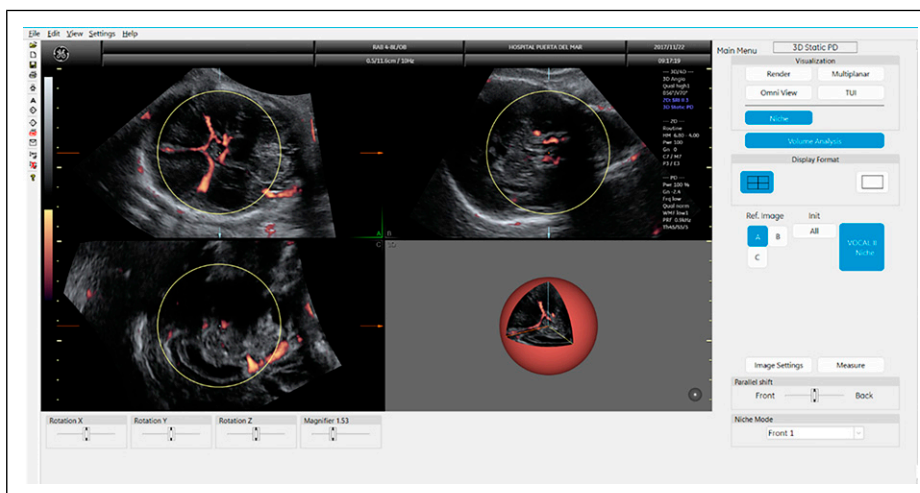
The fetal head 3DPD volume acquisition using VOCAL was set automatically to generate a sphere volume. 3DPD vascular indices were calculated automatically off-line by using the histogram facility. 3DPD: three-dimensional power Doppler.
